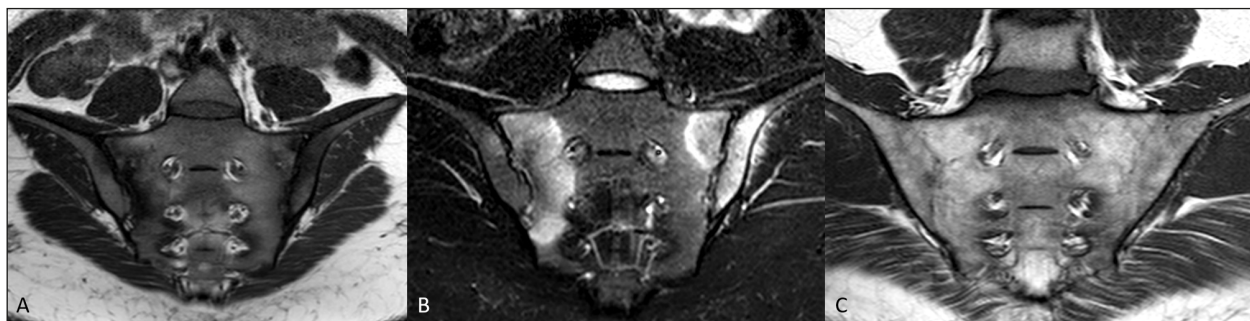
Patients with axial spondyloarthritis. Active sacroiliitis with bone marrow edema visible as hypointense areas in semi-coronal T1-weighted images (A) and hyperintense areas in semi-coronal short tau inversion recovery images (B), with typical distribution and extensive depth in the periarticular bone. Long-term axial spondyloarthritis with definite structural damage visible as ankylosis with continuous bone marrow signal intensity of iliac and sacral bone, and absent joint cavity (C).
